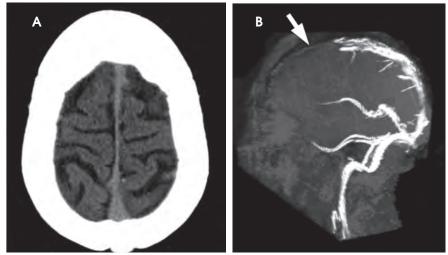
55-year-old man presenting with severe headache. (A) Unenhanced axial CT image is normal; the superior sagittal sinus does not appear hyperdense. (B) Maximum intensity projection of MR venogram demonstrates thrombosis of the anterior portion of the superior sagittal sinus (arrow).
